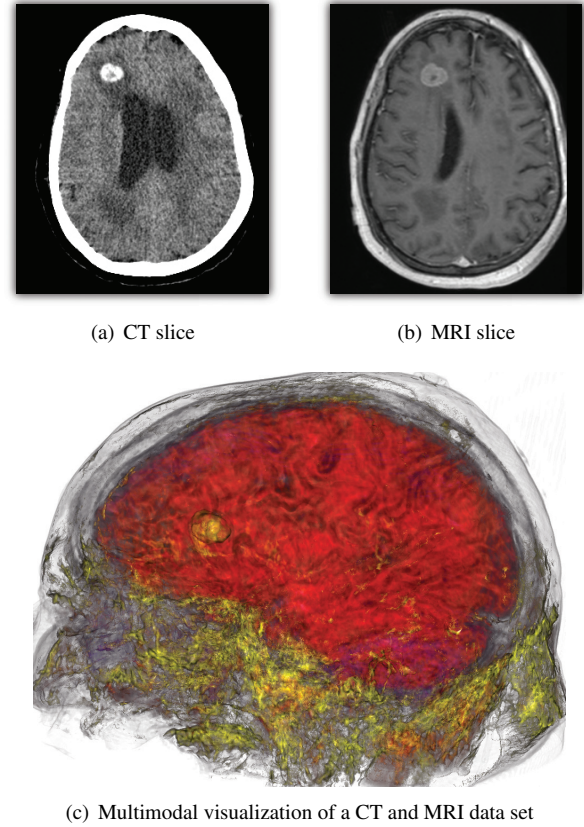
The multimodal rendering in (c) highlights a tumor in the brain, shown in the CT (a) and MRI (b) slice. Through the δ value the segmentation of the tumor is made easy because this region has a higher δ value than other surrounding parts.
